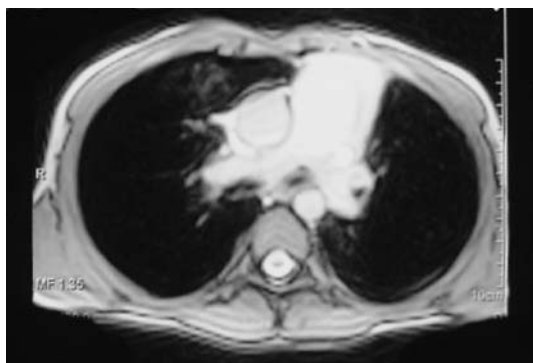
Axial T2-weighted spin-echo MR imaging of the thorax show no abnormality.
